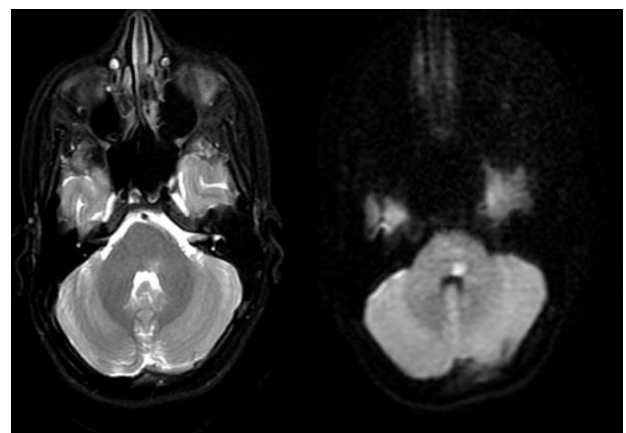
MRI brain of patient number 7 with pontine infarct.
